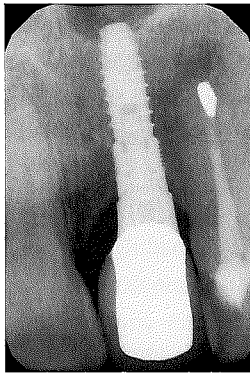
X-ray after 1 year.*
